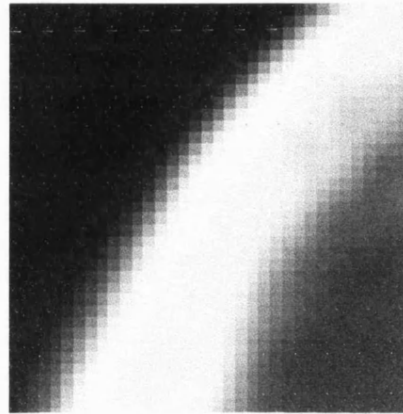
Enlarged View of CT Scan Image
